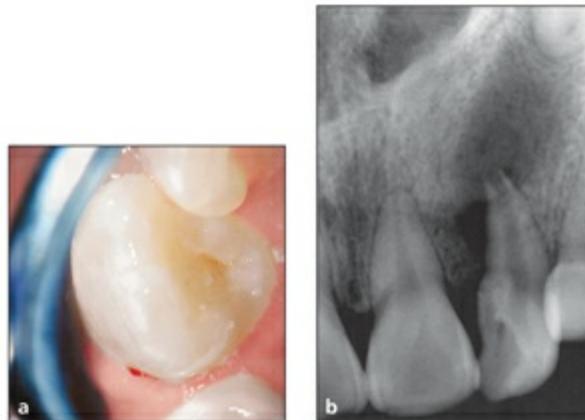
Clinical presentation (a) and radiograph (b) of a dens in dente. (Courtesy of Dr Yoav Shiloah, San Antonio, TX.)
